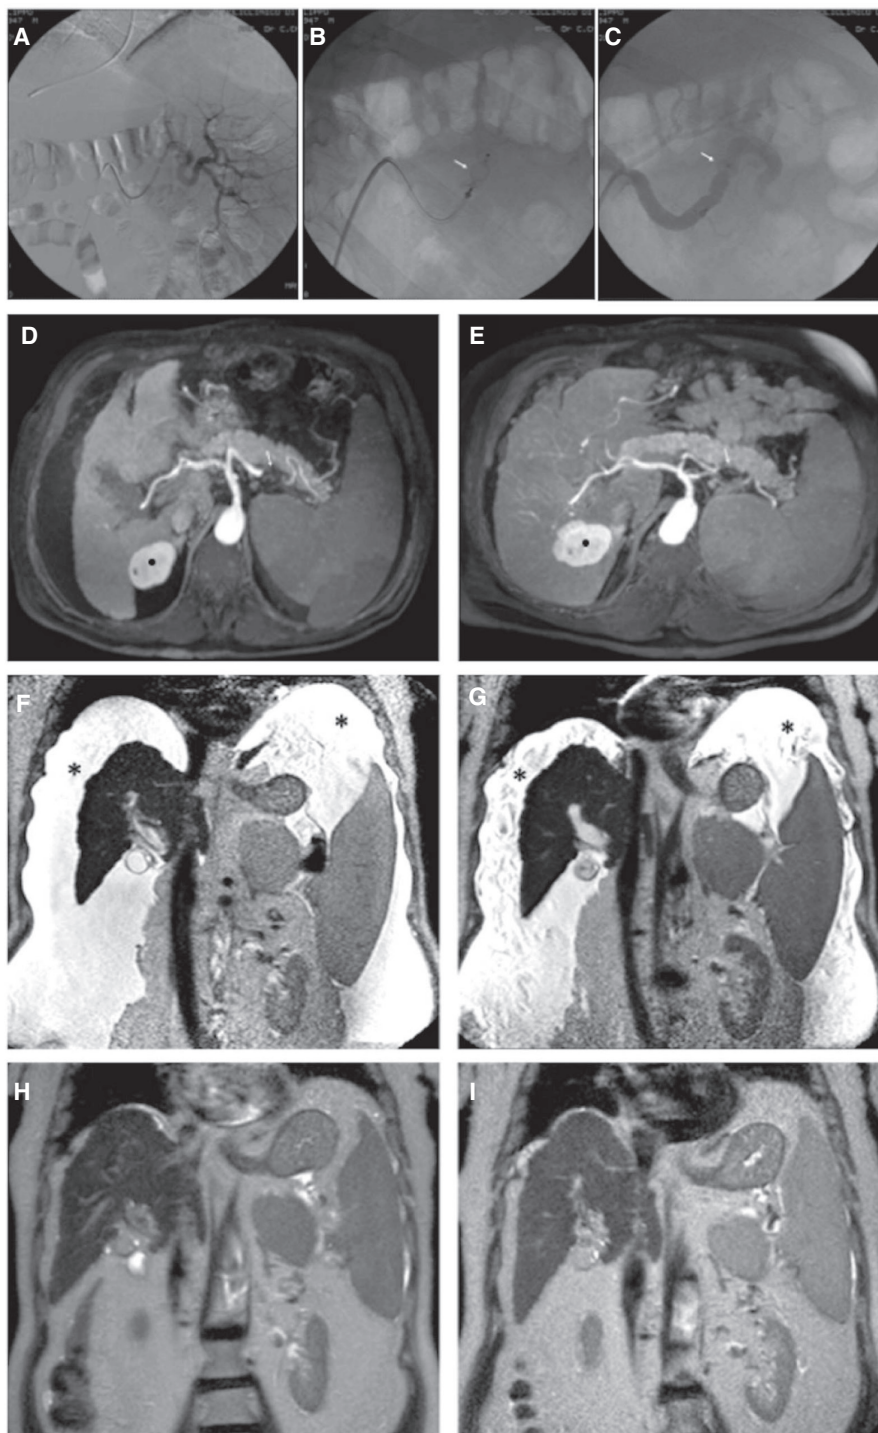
Arteriographic and MRI findings before and after PSAE. (A) Panoramic angiography of the splenic artery; (B) selective catheterization of the splenic artery and its embolization by deployment of a 10-mm obliterative plug (white arrow); (C) immediate postembolization contrast agent injection showing a reflux in other branches of the celiac trunk and a significant reduction of the blood flow beyond the plug. (D,E) Maximum intensity projection reconstructions on the axial plane of arterial phase T1-weighted three-dimensional gradient-echo MRI sequences taken 2 (D) and 15 months (E) after PSAE, respectively. Contrast agent in the portion of the splenic artery distal to the obliterative plug indicates perfusion of the spleen through collateral arteries. White arrows indicate the plug inside the splenic artery. An increase of liver volume is evident in (E). The black dot indicates the upper pole of the right kidney. (F-I) Coronal single-shot T2-weighted MRI sequences taken the day after PSAE and 1 week, 2 months, and 15 months later. White asterisk indicates ascites.
